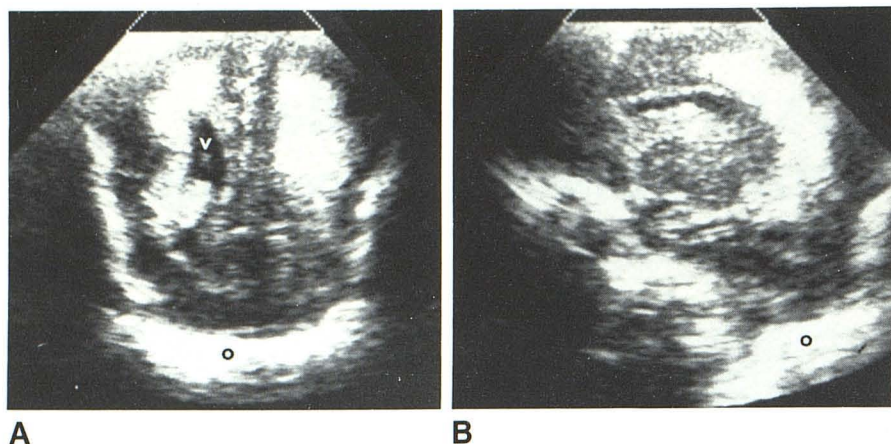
Premature neonate with hemorrhagic PVL proven by CT. A, Axial sonogram showing periventricular echogenicity. B, Angled sagittal view with dense echoes surrounding posterior ventricular body and trigone. v = ventricle, o = occipital bone.
